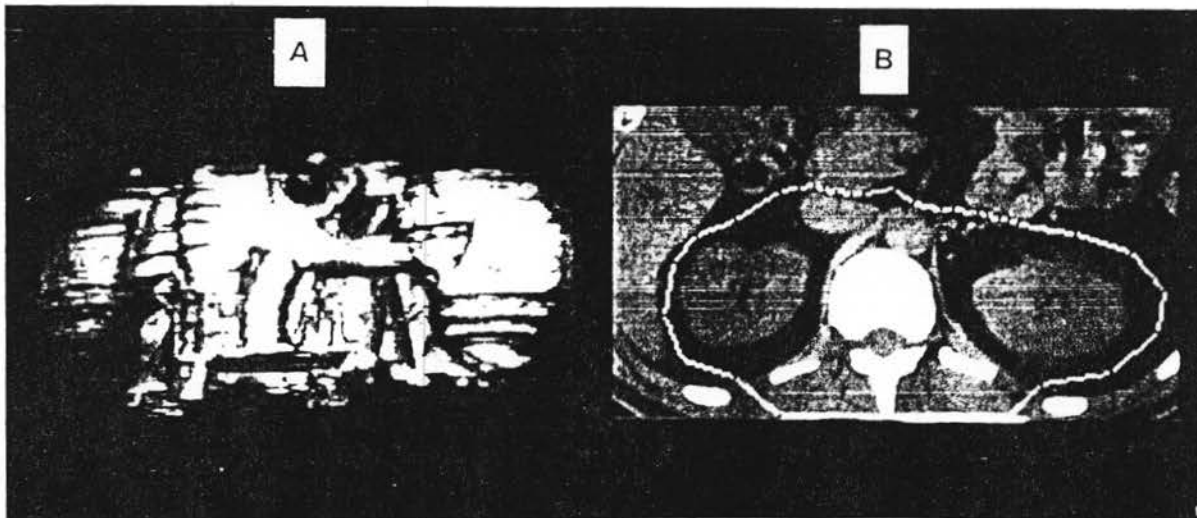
Volume rendering of kidneys from CT DATA (7a), with one slice (7b) showing included ROI.
